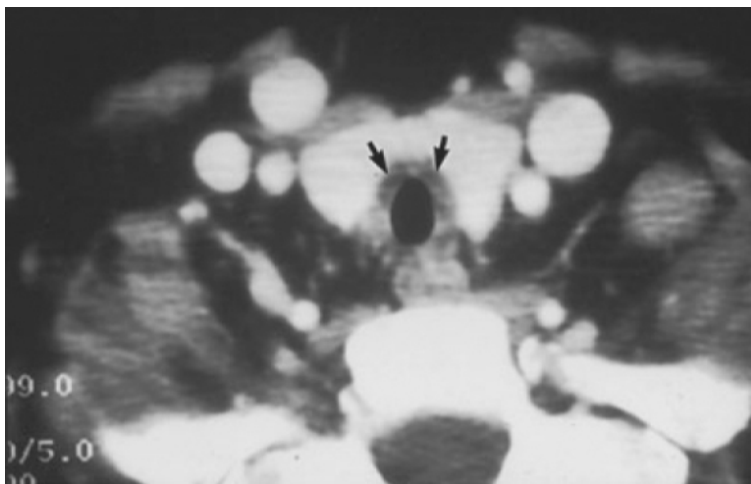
Computed tomography scan of a patient with active relapsing polychondritis demonstrating edema of the perichondrium of the cricoid cartilage and resorption of the cartilage (*arrows*).
